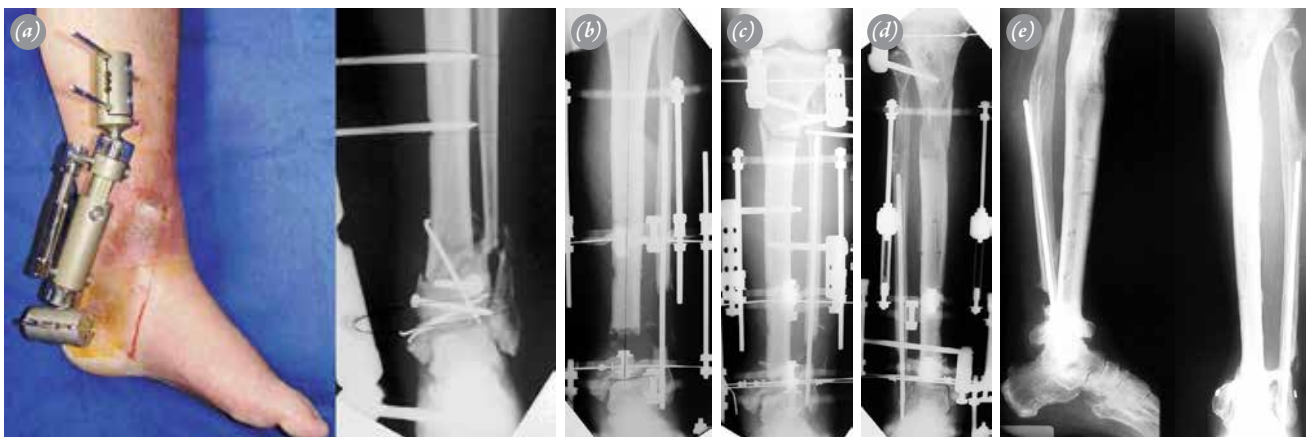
Case 6, a 53-year-old man with surgical site infection-related osteomyelitis of the distal third of the left tibia. (a) Photograph taken when the patient was first evaluated, showing failed monolateral external fixation with a wound over the anteromedial aspect of the left leg. Plain radiograph taken at presentation showing the first operation; the bone had not united. (b) Radiograph taken after radical debridement and resection of the infected bone before acute shortening intraoperatively. (c) Postoperative anteroposterior radiograph showing the distal compression site and the proximal osteotomy site within the circular external fixator. (d) Plain radiograph taken when the proximal lengthening site and distal compression site had united before external fixator removal. (e) Anteroposterior and lateral radiographs showing union. [Color figures can be viewed in the online issue, which is available at www.aott.org.tr]
